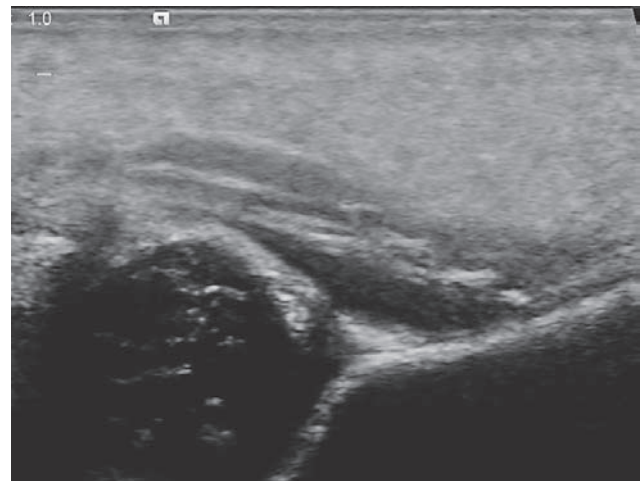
Necrosis of subcutaneous fat tissue, presented as extremely increased echogenicity of subcutaneous fat on ultrasonography
